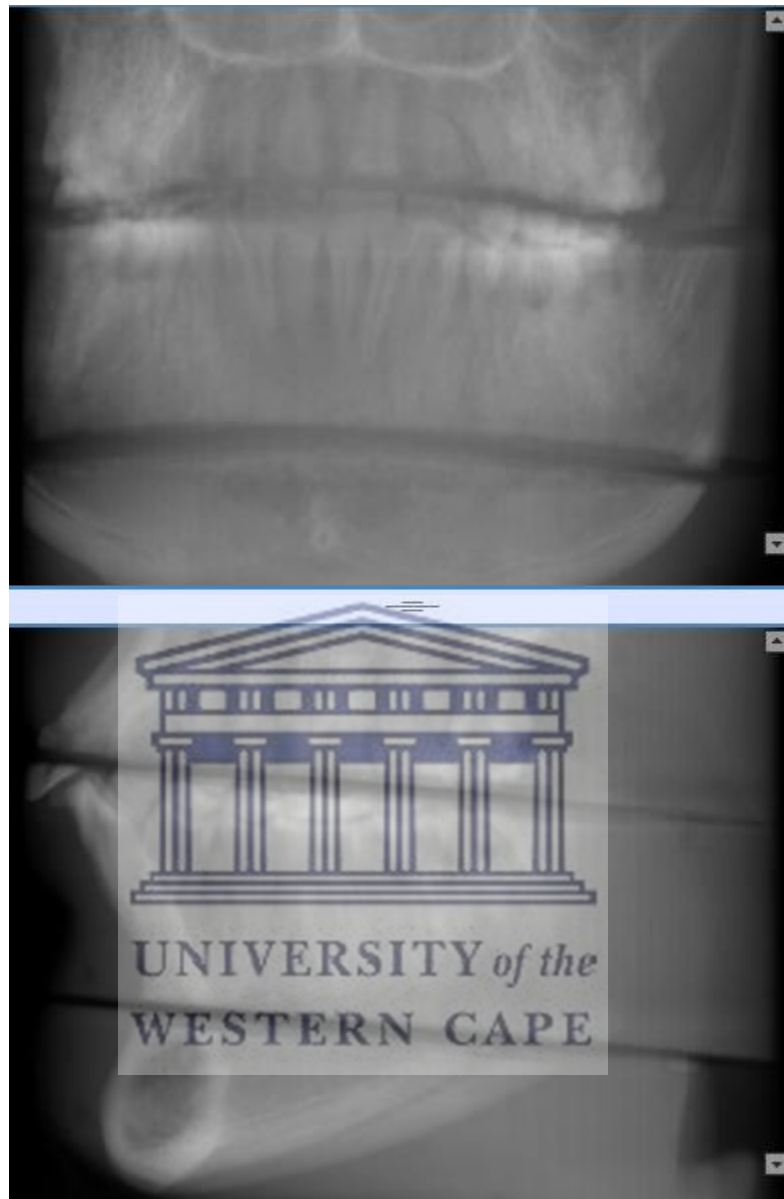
AP (top) and lateral cephalometric (bottom) radiographic views of the acquired CBCT volume (NewTom® 5GXL, FOV 8 × 8 cm, regular scan, and standard dose).
